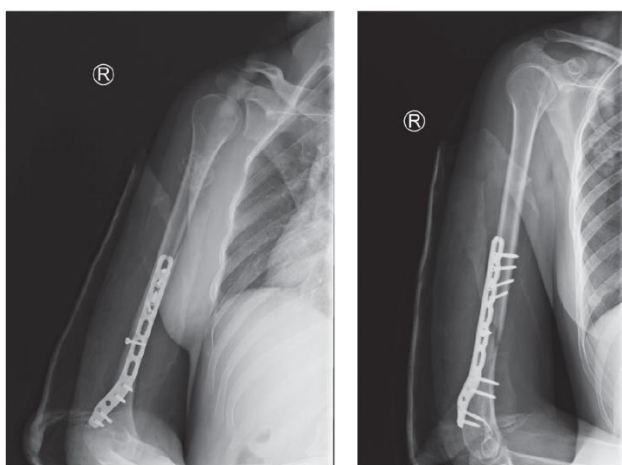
X-ray images of patient B., front and lateral views. Plate osteosynthesis of the humerus. Satisfactory position of fragments and fixator
